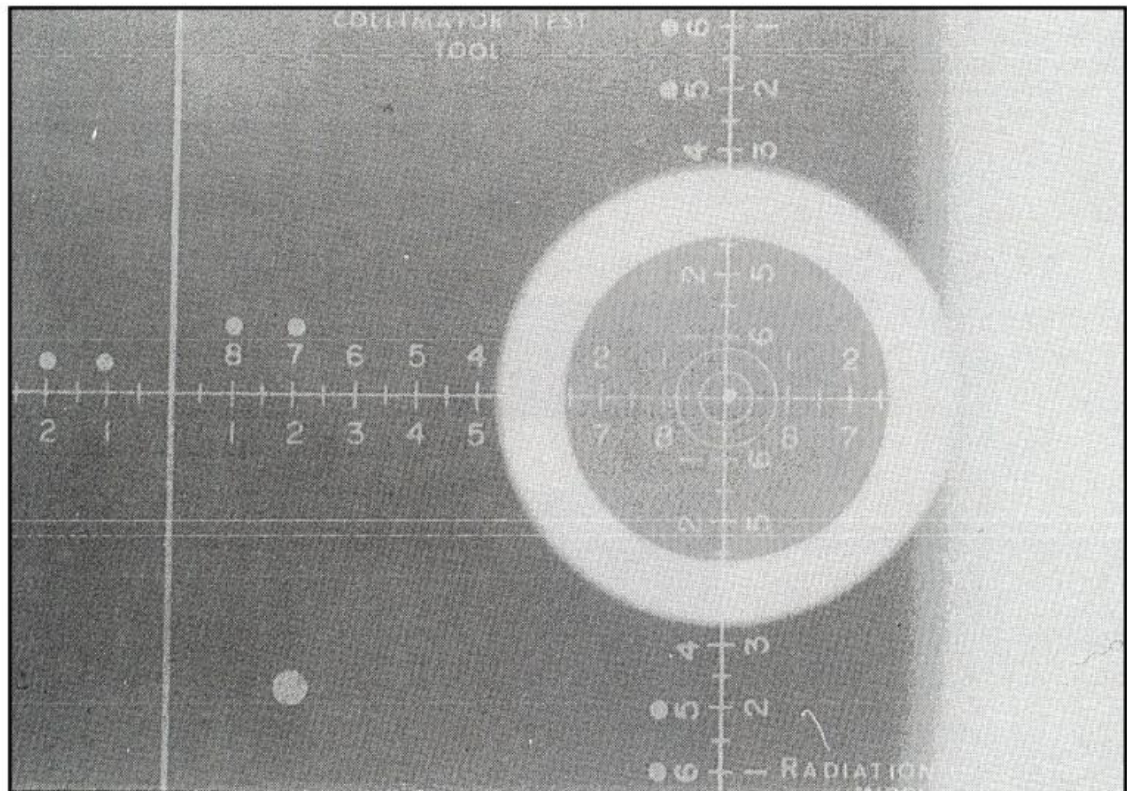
(c): X-ray field alignment error, greater than 3 cm and unacceptable at 40'' SID
